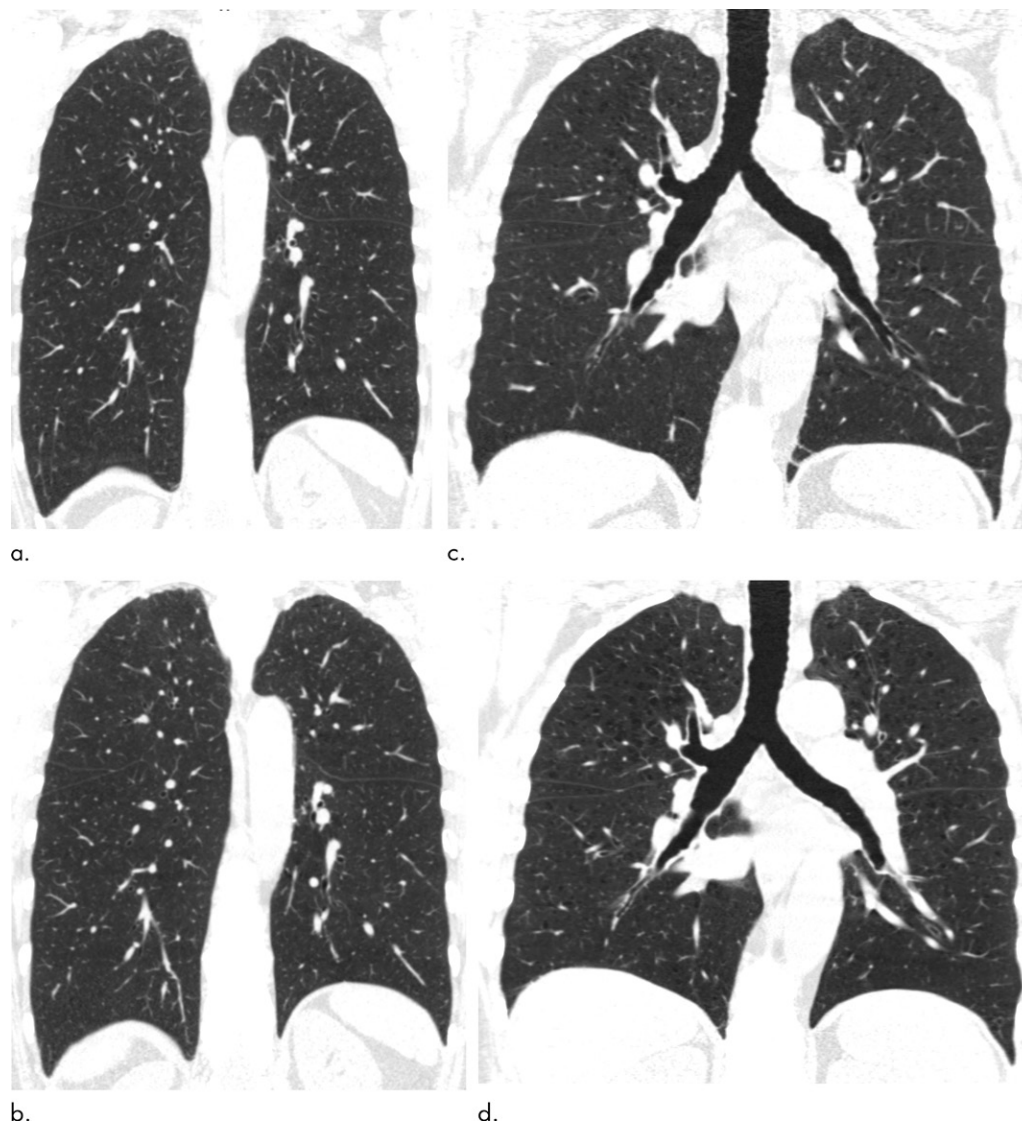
Baseline and 5-year follow up inspiratory CT scans in two Global Initiative for Chronic Obstructive Lung Disease stage 0 participants showing no progression and progression. (a) Baseline and (b) 5-year follow-up scans in a 55-year-old female participant without visually evident emphysema and no interval progression at follow-up. Forced expiratory volume in 1 second (FEV_1) decreased by 62 mL. (c) Baseline and (d) 5-year follow-up scans in a 49-year-old male participant with trace emphysema at baseline but progression to moderate emphysema at follow-up. FEV_1 decreased by 780 mL between visits.
